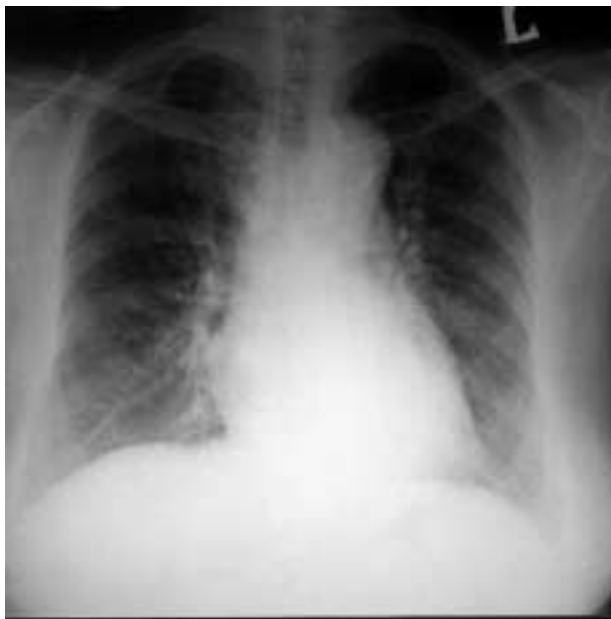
Chest radiograph taken 2 weeks after stopping steroid treatment; showing no recurrence of pulmonary infiltrates.
